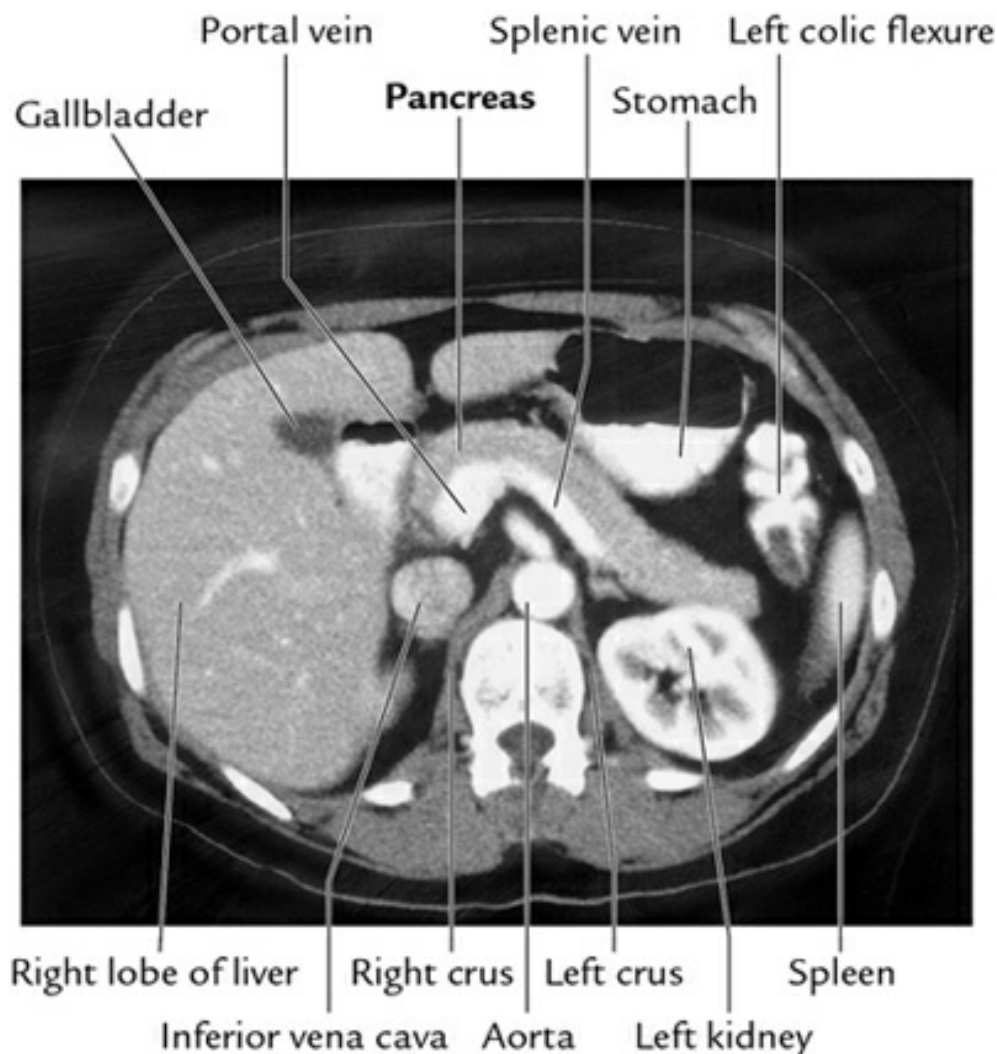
■ CT scan of the abdomen with contrast in an axial plane. (Source: Fig. 4.88A, Page 289, *Gray's Anatomy for Students*, Richard L Drake, Wayne Vogl, Adam WM Mitchell.
